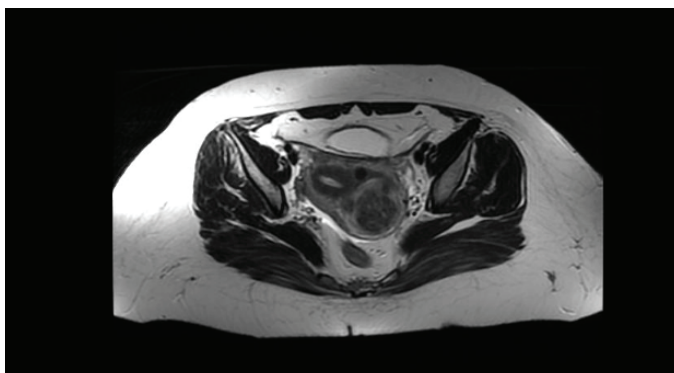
54 mm type 2 leiomyoma shown in the magnetic resonance imaging before uterine artery embolization
